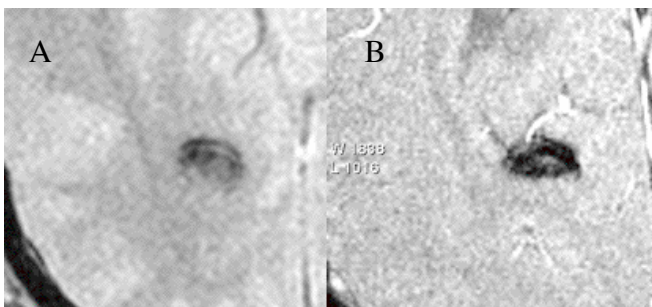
Compared to standard (1.5T) MRI (a), 3T HR-SW-MRI (b) allows superior detection of cerebral cavernomas.
